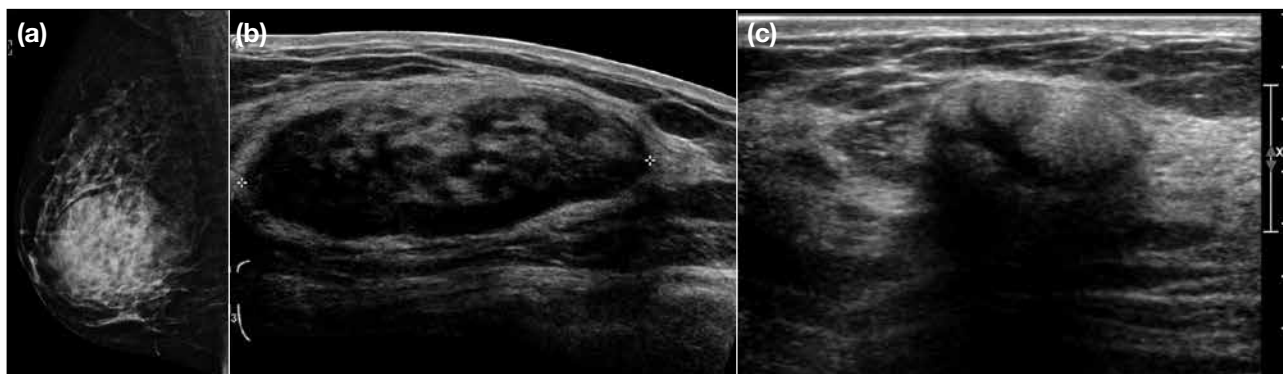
A 48-year-old woman presented with a painless palpable mass in the right breast. (a) Mammogram showing mass of mixed fat and equal density with a lucent rim. Ultrasonogram showing an oval circumscribed heterogeneous mass with hyperechoic areas, likely corresponding to fat component. Findings are typical of a breast hamartoma. (c) A 59-year-old woman presented with a painless palpable right breast mass. Ultrasonogram showing an oval circumscribed echogenic mass with posterior shadowing, pathologically proven to be a hamartoma.
